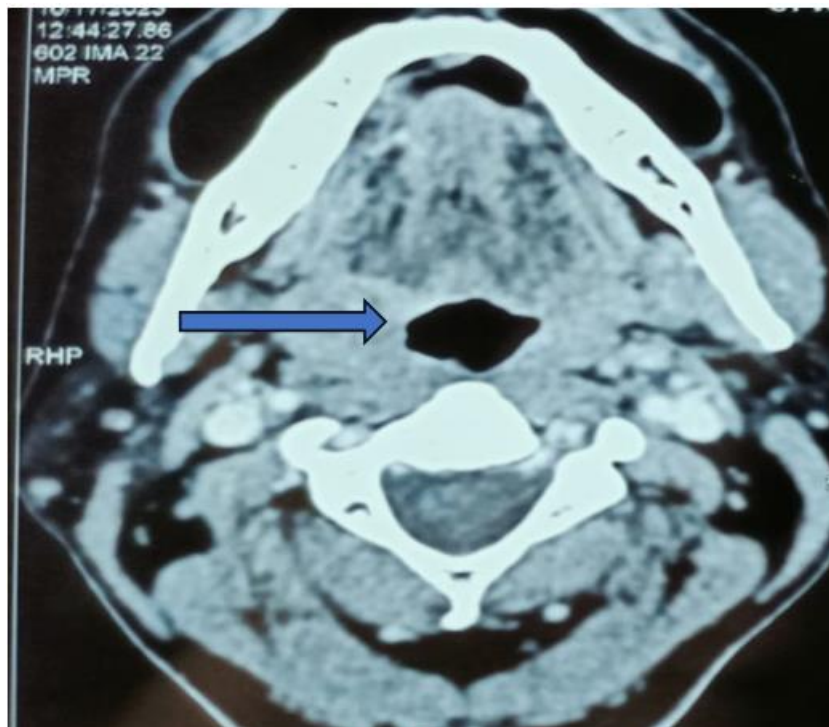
Computed tomography in axial view showing a well - defined enhancing lobulated mass in right vallecular region (blue arrow)
